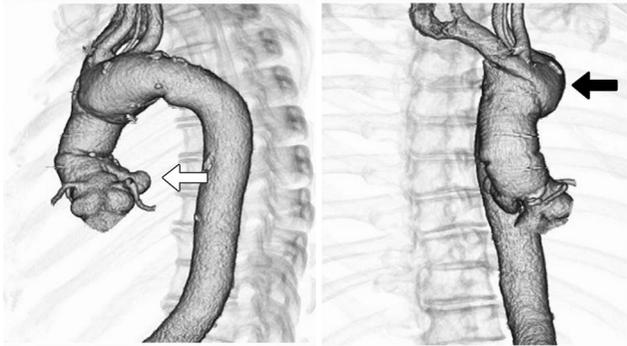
A preoperative computed tomography scan showed pseudoaneurysm formation at the proximal anastomotic site, which was a saccular-type aneurysm (white arrow), and residual dissection at the distal anastomotic site (black arrow).
